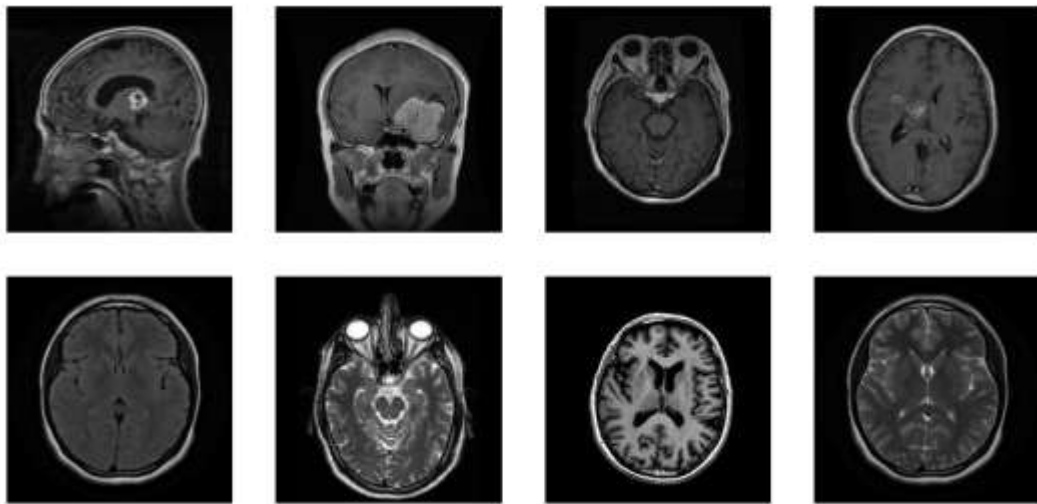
Representative MRI images from the dataset: abnormal scans with brain tumors (top row) and normal scans without tumors (bottom row).
